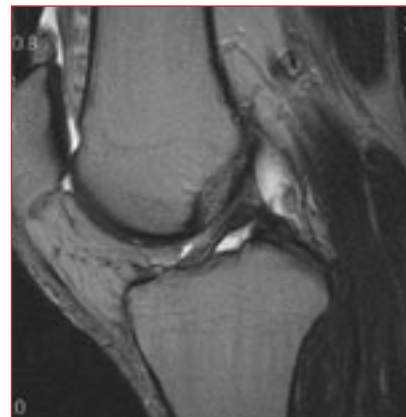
MRI of the knee shows normal anterior cruciate ligament.
